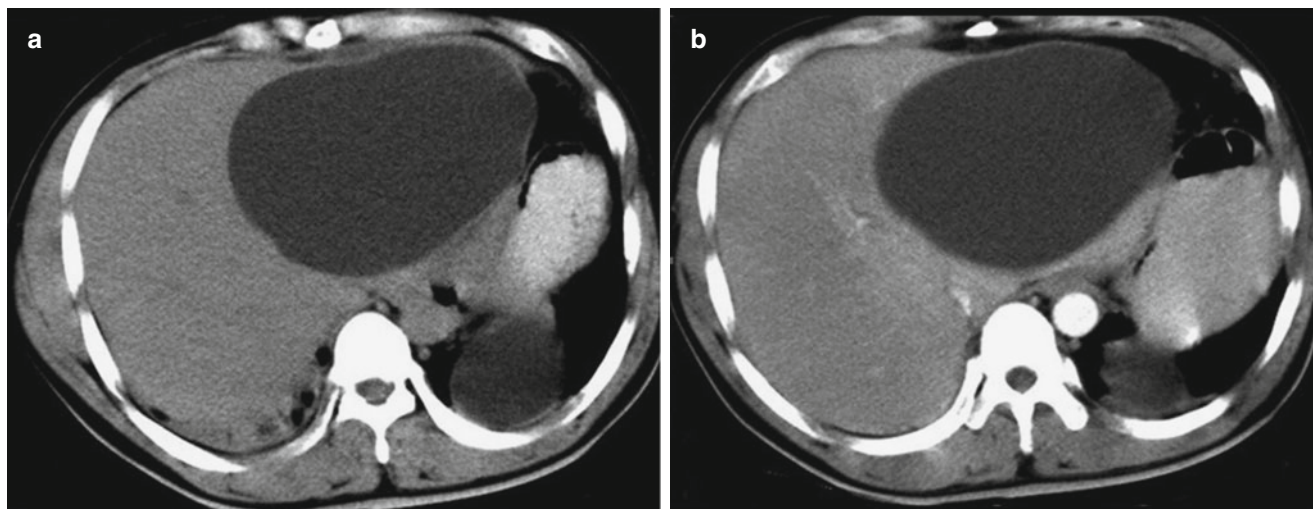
Hepatic cystic hydatidosis (simplex cystic type). (a) Plain CT scanning demonstrates oval-shaped low-density shadow in the left liver lobe, with smooth and sharp margin and even density. The cystic
